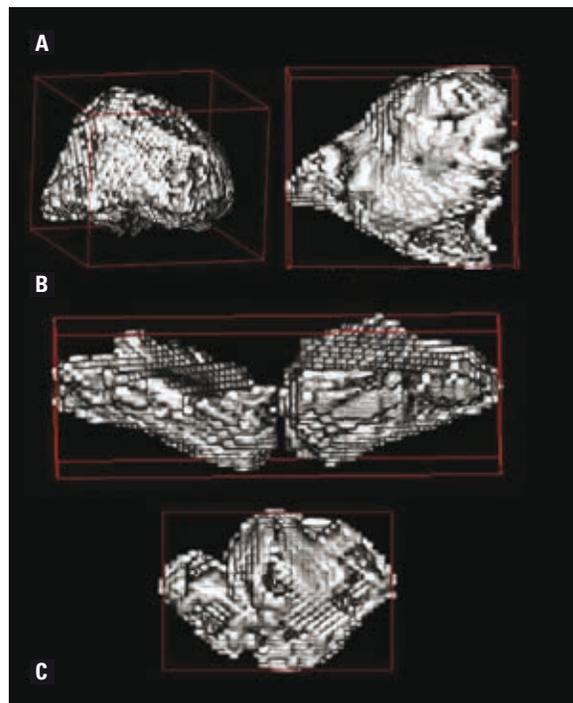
Measurement sites related to paranasal sinuses on the cone beam computed tomography images; A. Coronal and axial view of the frontal sinus; B. Coronal and axial view of the sphenoid sinus; C. Coronal and axial view of the maxillary sinus.
